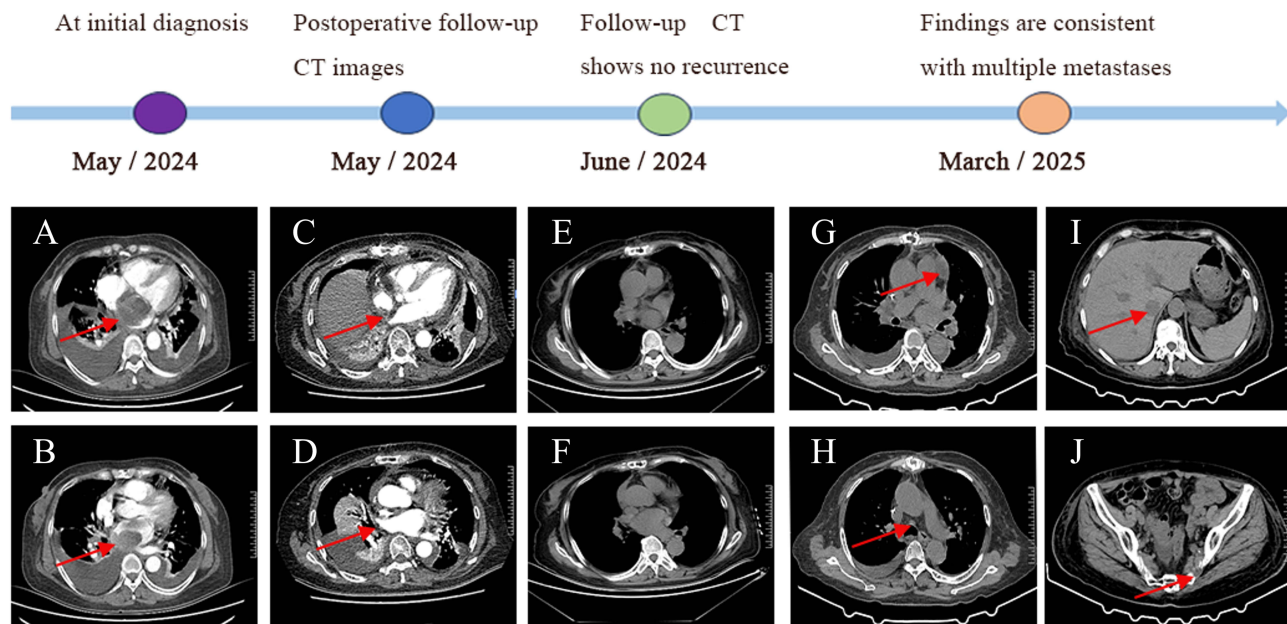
Postoperative radiological surveillance timeline. (A and B) Preoperative baseline imaging (for detailed characterization, refer to Figure 1). (C and D) Initial postoperative CT scan in May 2024 confirms complete tumor resection (red arrows) with no evidence of residual disease. (E and F) Follow-up CT scan in June 2024 shows no signs of local recurrence. (G–J) Surveillance imaging in March 2025 reveals widespread metastases (indicated by arrows), including hypodense nodules adjacent to the left pulmonary artery and the ascending aorta, an osteolytic lesion in the left iliac bone, and a new hepatic metastasis.
